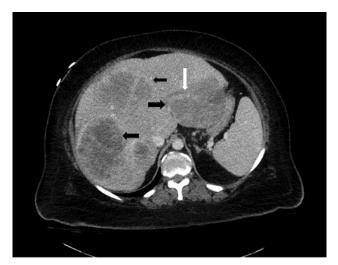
CT scan of the abdomen/pelvis with iv contrast showing multiple liver masses with intraparenchymal hemorrhage. White arrow indicates areas of active contrast extravasation and black arrows indicate the liver masses.
